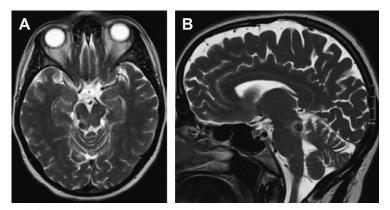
T2-weighted (A) axial and (B) sagittal MRI of a patient with a right dorsolateral cavernoma of the midbrain.
